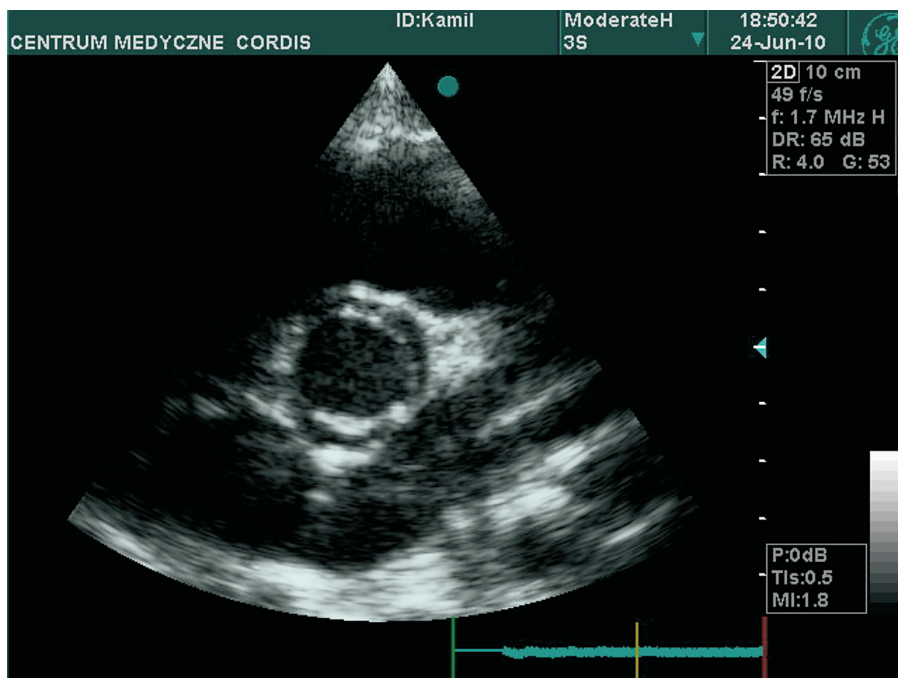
Echocardiography. Bicuspid aortic valve (AS)
